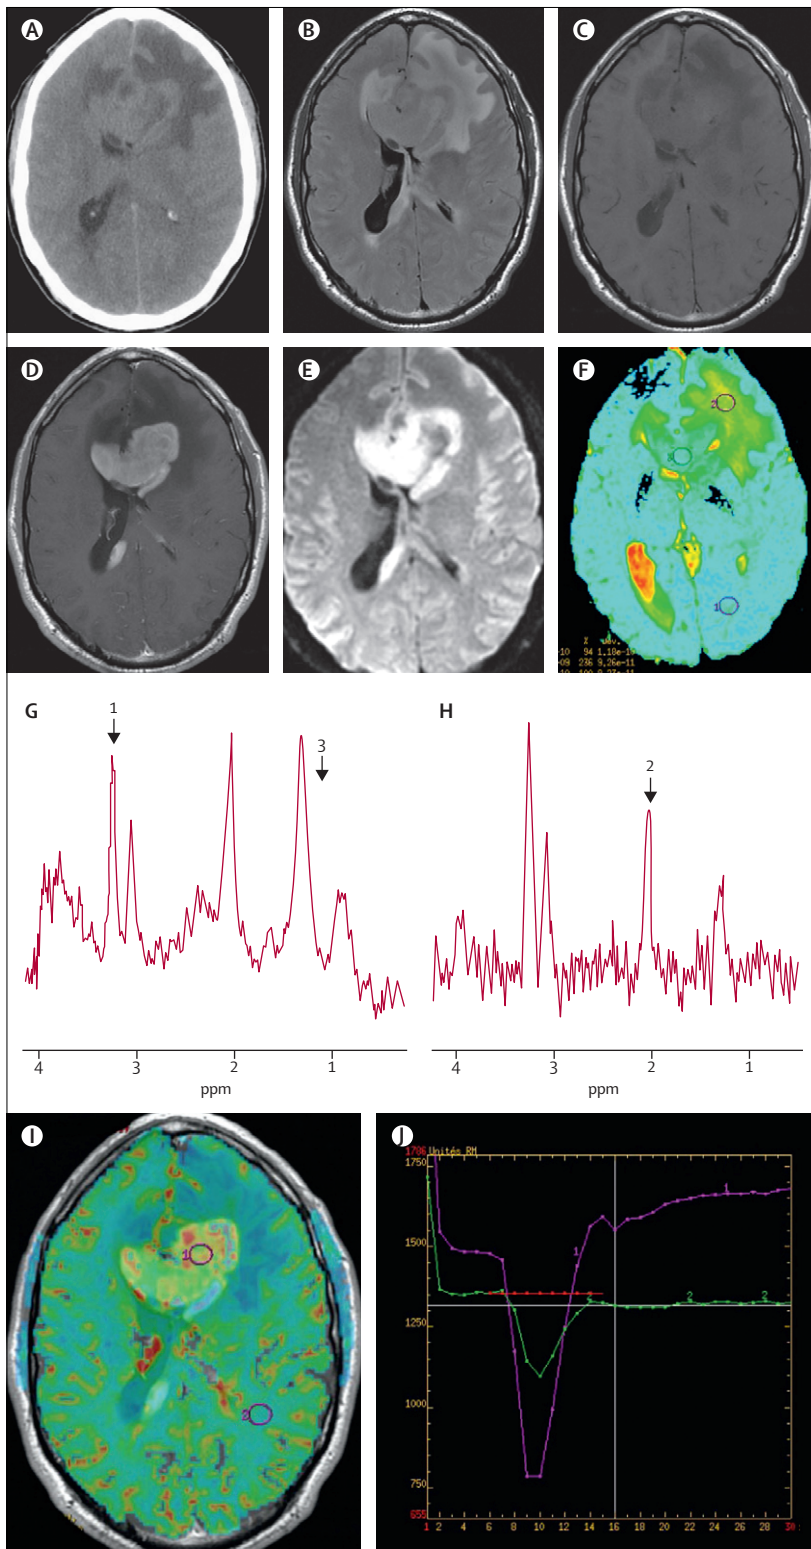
Multimodality MRI scan of the brain of a middle-aged man with a primary CNS lymphoma
